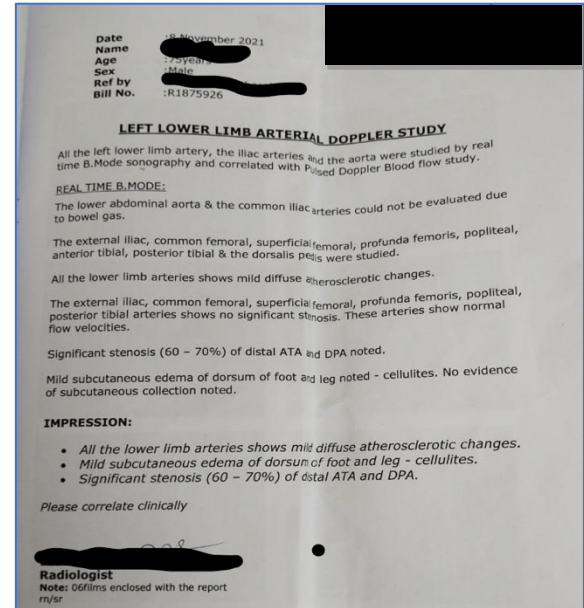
Investigations –Arterial Doppler study Before treatment
